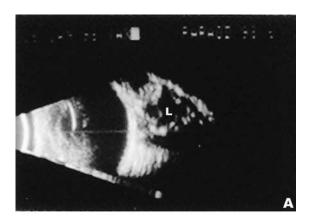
Vascular lesions: (A–C) cavernous hemangioma and (D–F) lymphangioma. (A) Axial CT scan shows welldelineated intraconal mass (M) in the left orbit. (B) B scan displays a well-defined round to ovoid echogenic lesion (L). (C) Ascan reveals multiple, regular, highly reflective echo spikes with the descending edges reaching a medium reflectivity indicating the presence of blood within the venous spaces and the abundant connective tissue septae.⁹ Sound attenuation is moderate (angle $\kappa = 45^{\circ}$). Color Doppler imaging shows little or no evidence of blood flow attributable to the stagnant blood within the vascular spaces.¹⁰ (D) Axial CT scan shows an irregular mass (M) in the right orbit. (E) B scan displays an irregular, large lesion (L) with multiple, dilated lymph-filled spaces (arrows).^{2,11} (F) A scan reveals a regular, heterogeneous pattern with highly reflective echo spikes separated by low reflective, dilated lymphatic spaces. In contrast to cavernous hemangiomas, the presence of clear fluid instead of blood in the wider intracavernous spaces of lymphangiomas provides ample time for the ultrasound beam to reach lower reflective levels (arrows).⁵ Sound attenuation is moderately low (angle $\kappa < 30^{\circ}$).
